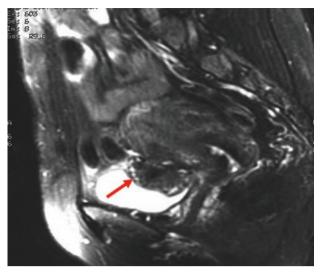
Magnetic resonance imaging shows a nodular mass in the anterior fornix adjacent to the uterine wall (arrow), causing extensive compression of the posterior bladder wall (note the absence of concomitant uterine adenomyosis): sagittal image
